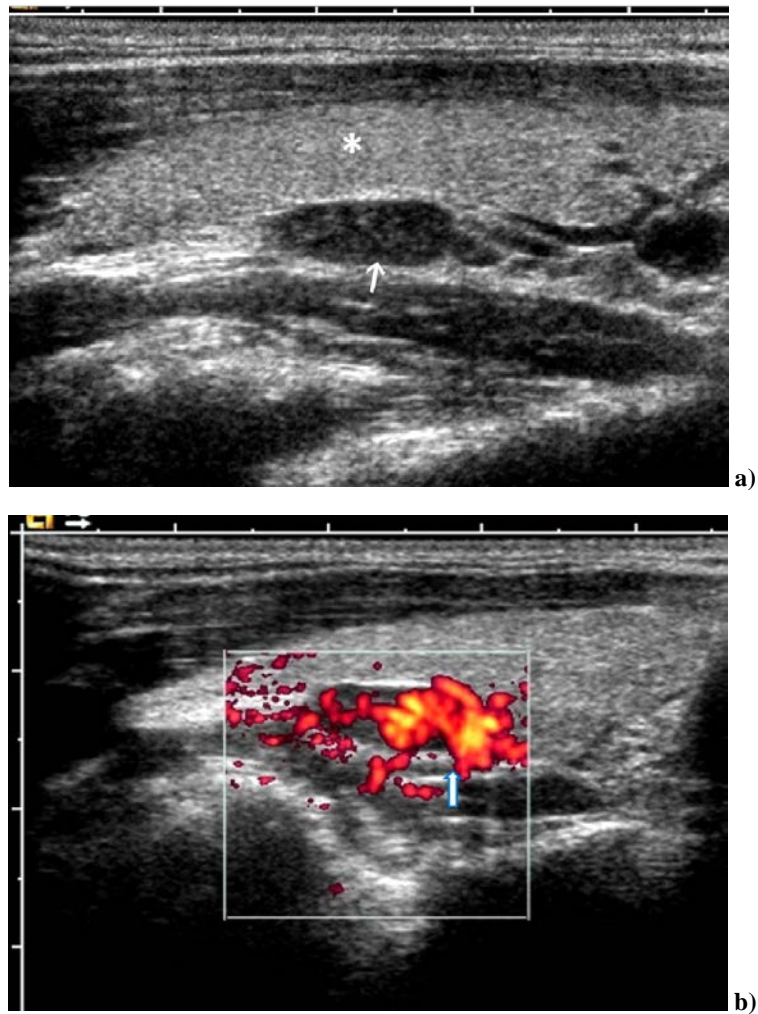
Adenoma (primary hyperparathyroidism – pHPT): a) ultrasonographic appearance of a parathyroid adenoma (gray scale) appearing as a solid, oval, hypoechoic lesion with a well-defined margin, located under the upper pole of the right thyroid lobe (marked by an asterisk); b) the same adenoma visualized by Power Doppler. Note extrathyroidal feeding blood vessels entering at the parathyroid gland (white arrow).
